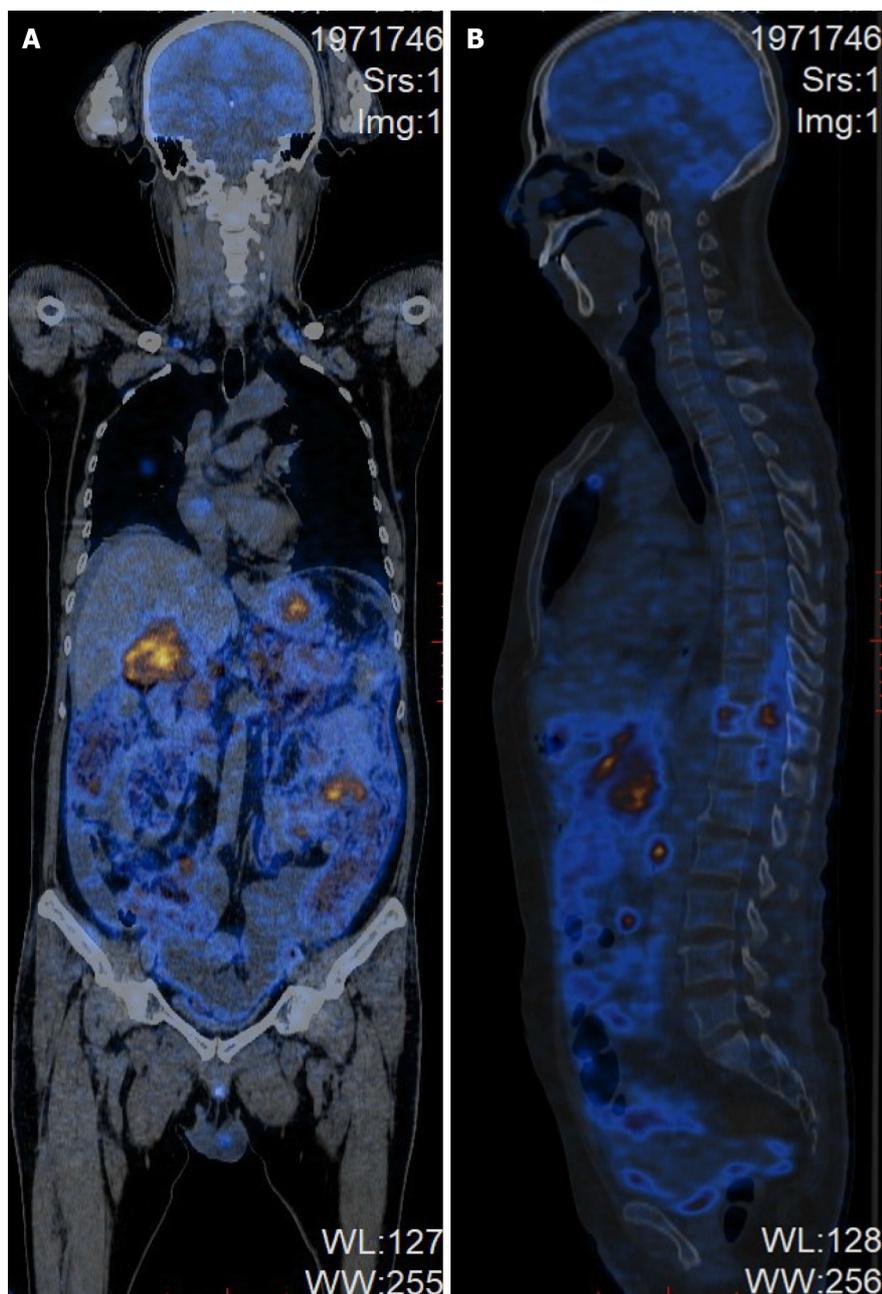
Positron emission tomography-computed tomography of the whole body at diagnosis. A: Coronal images; B: Sagittal images.
